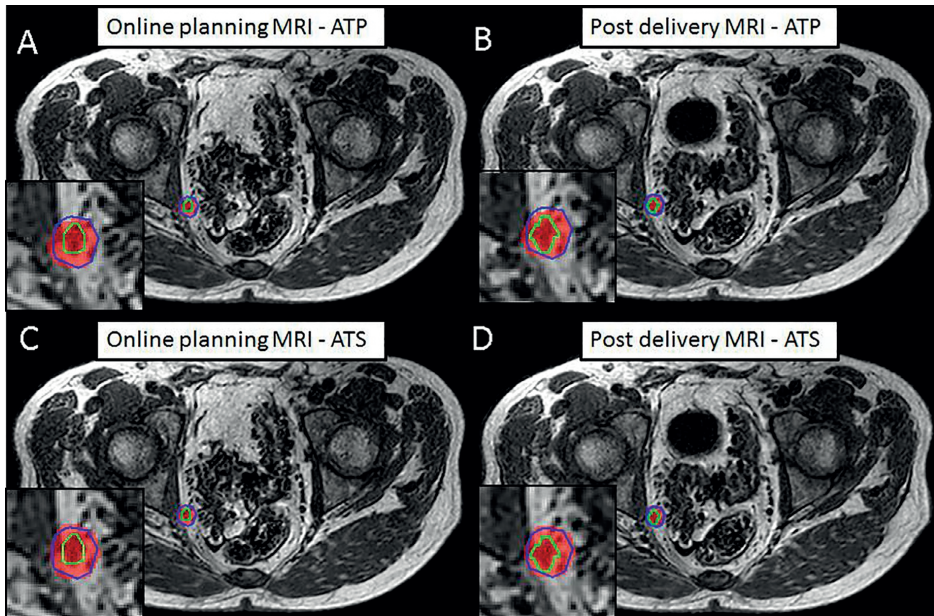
Sample case with intra-fraction expansion of the bladder due to increased filling. Visible are the 35 Gy dose level (red), the PTV (blue) and the actual location of the GTV (green) for the ATP plan on the online planning MRI (A) and the post-delivery MRI (B) and the ATS plan on the online planning MRI (C) and the post-delivery MRI (D). The GTV $V_{35\text{Gy}}$ remained 100% for the clinically delivered (ATS) plan. For this particular case the increasing bladder filling and GTV shift resulted in a small reduction of GTV $V_{35\text{Gy}}$ from 100% to 97.5% with the ATP plan.
